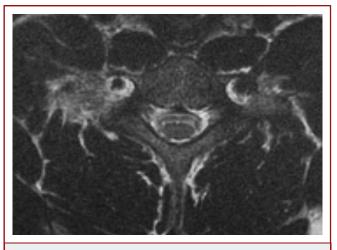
Axial T2-weighted magnetic resonance imaging at the C7 level depicting edema around the transverse process on the right.
